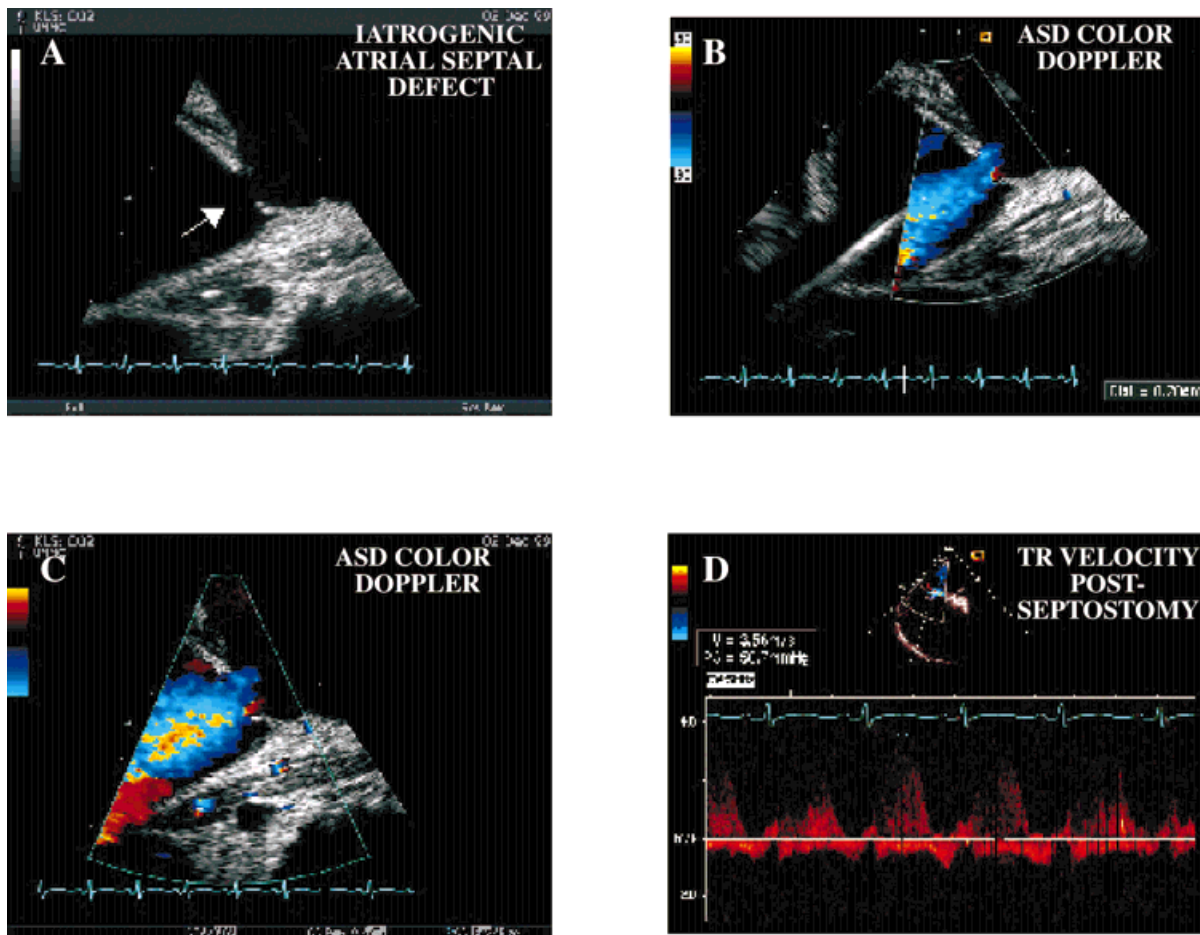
A: Iatrogenic atrial septal defect (ASD). B and C: Color Doppler flow through a moderate-size ASD with continuous right-to-left flow. D: Tricuspid regurgitant velocity.
